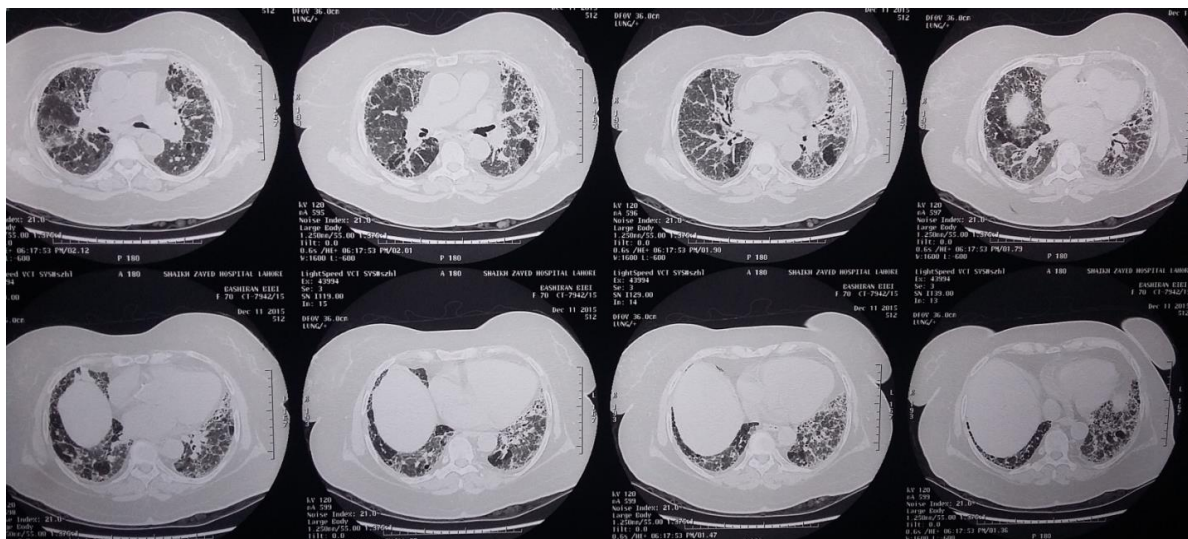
HRCT chest imaging from the level below the carina to lung bases showing bilateral diffuse GGOs, interspersed with fibrotic foci characterized by interlobar and intralobular septal thickening and honey combing. Right upper and left lower lobes show more fibrotic lesions compared to left upper and right lower lobes containing more GGOs.
